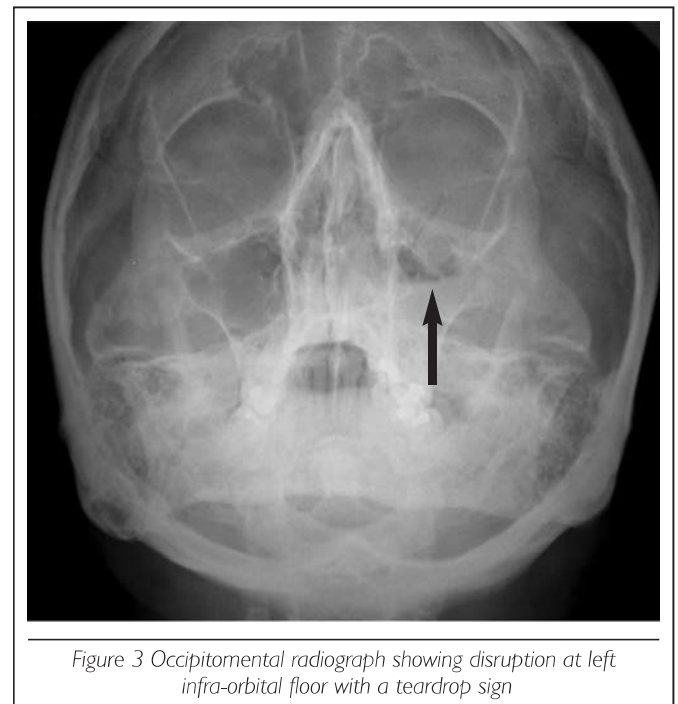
Occipitomental radiograph showing disruption at left infra-orbital floor with a teardrop sign
